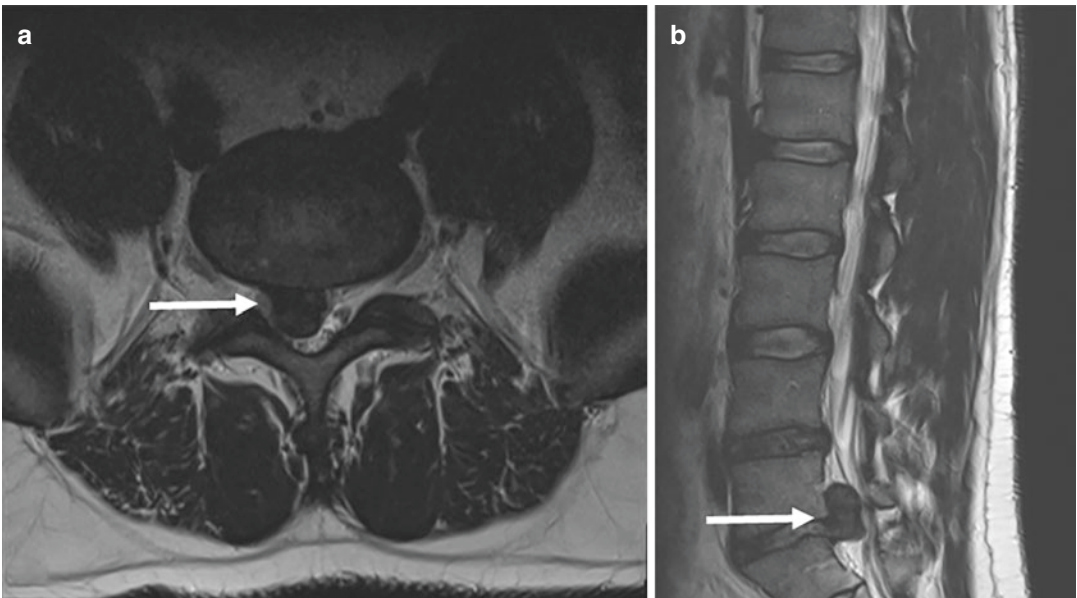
Spontaneous epidural hematoma. (a) Axial T2-weighted MRI of the lumbar spine shows a large right central disc extrusion (arrow) that impinges on the central
